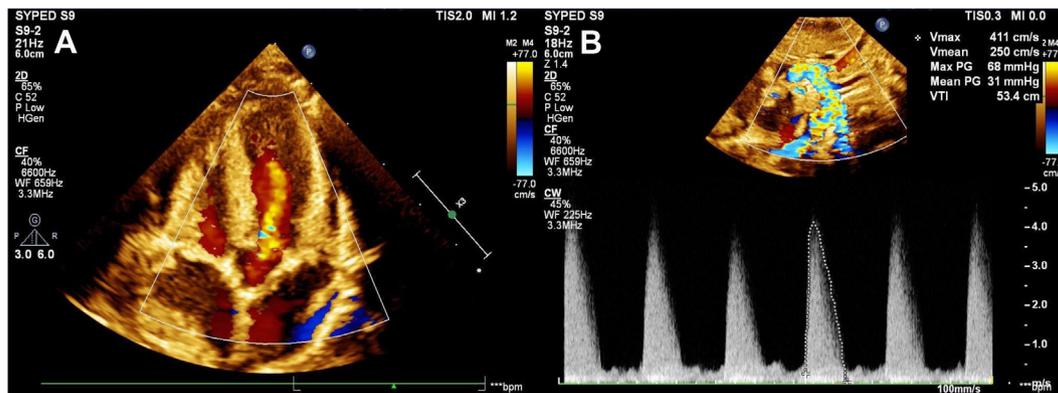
(A) Two-dimensional TTE, apical 5-chamber view with color Doppler, diastolic phase, demonstrates moderate aortic valve regurgitation. (B) Two-dimensional TTE, suprasternal notch view with color-guided continuous-wave spectral Doppler interrogation confirms a high-velocity jet of 4.11 m/sec corresponding to a peak gradient of 68 mm Hg.
